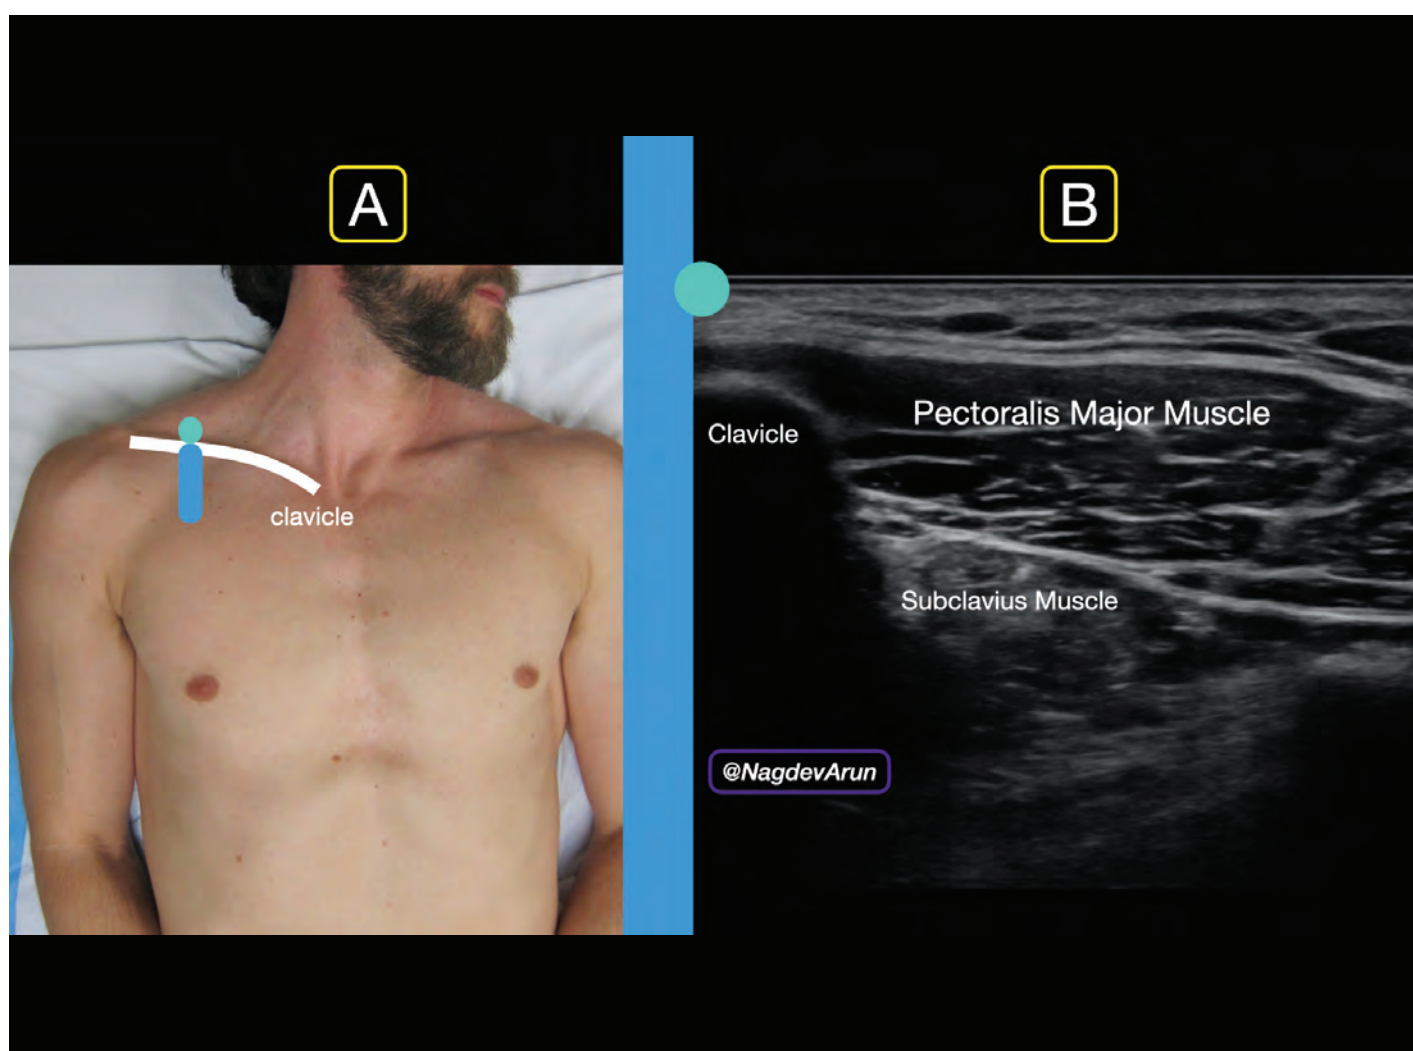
Ultrasound probe should be placed at the clavicle with the probe marker facing cephalad (toward the head).
